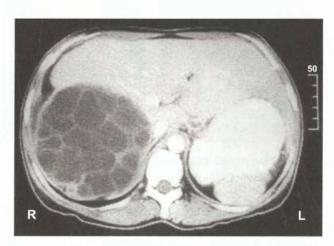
CT scan of the liver showing classical cart wheel pattern—coronal section
